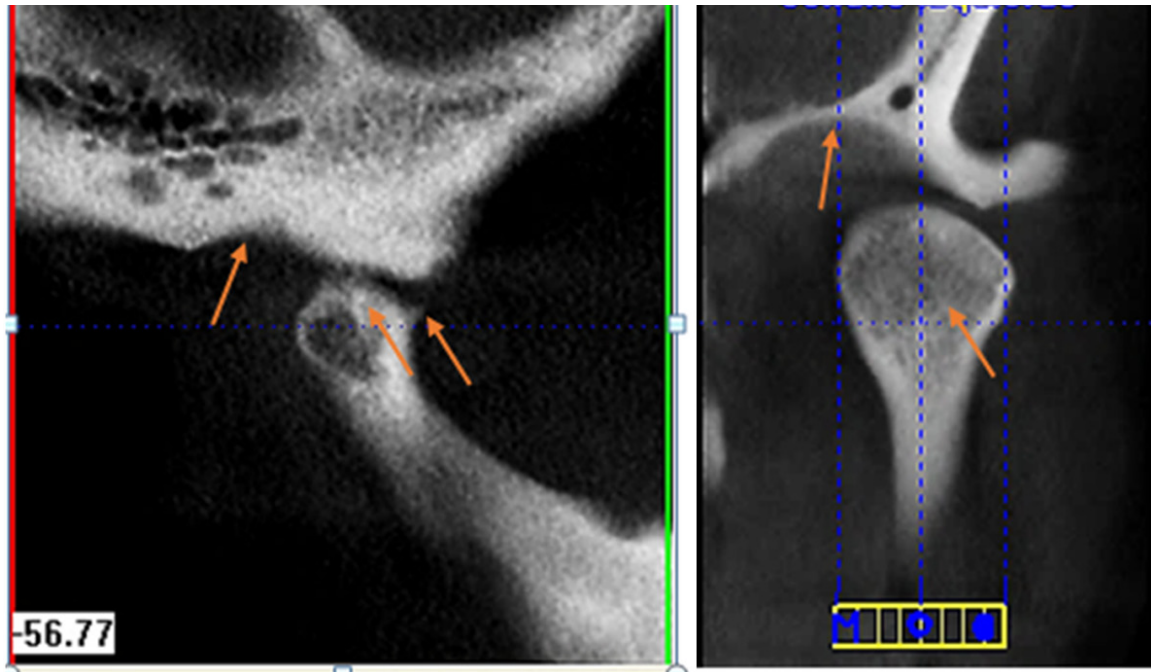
CT images of Female 56 years old. Left hand side: right condyle. Right hand side: left condyle. Observe the erosion in both temporalis. Flattening condyle and temporal law. Osteophyte in right condyle. Osteophytes in temporal and left condyle.
